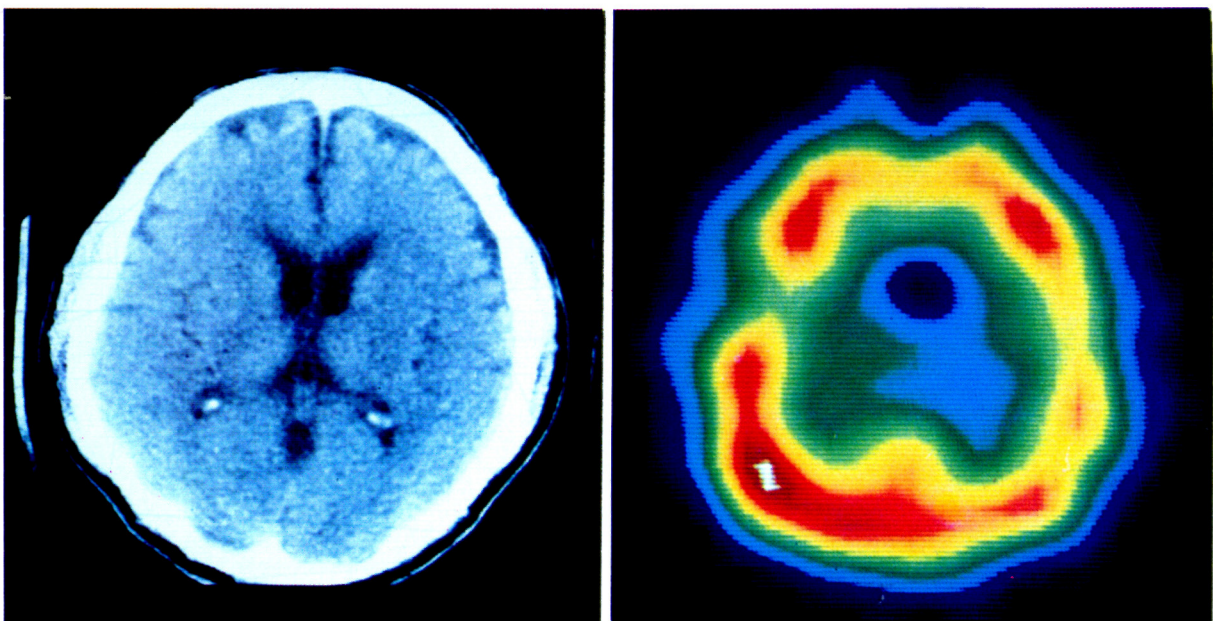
The patient, with hypertension for 10 years, had right hemisensory deficit and a weak right leg. CT (left) revealed only diffuse cortical atrophy, but bilateral cortical areas of decreased perfusion (worse on the left side) were observed on SPECT (right). His MR image demonstrated multiple small high-signal intensity lesions, while severe atherosclerotic stenosis of both internal carotid arteries was found on cerebral angiography.
